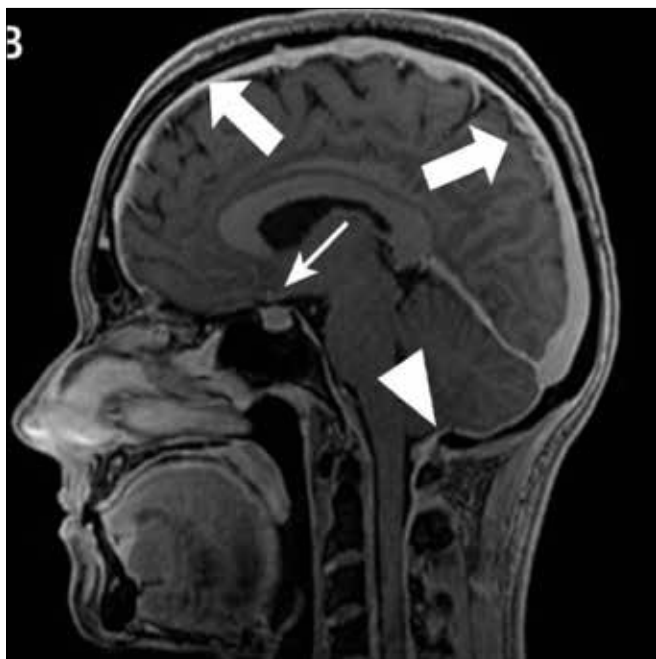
Sagittal MRI with gadolinium showing: a) Diffuse pachymeningeal enhancement + dural thickening (thick arrows), b) Prominent homogeneously enhancing pituitary gland (thin arrow) (1)
